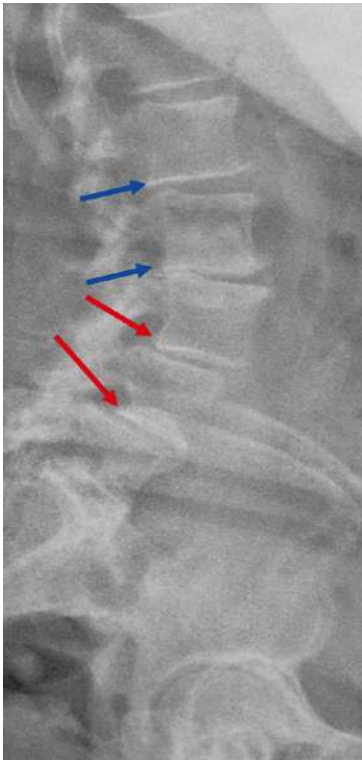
Retrolisthesis on lateral X-ray
